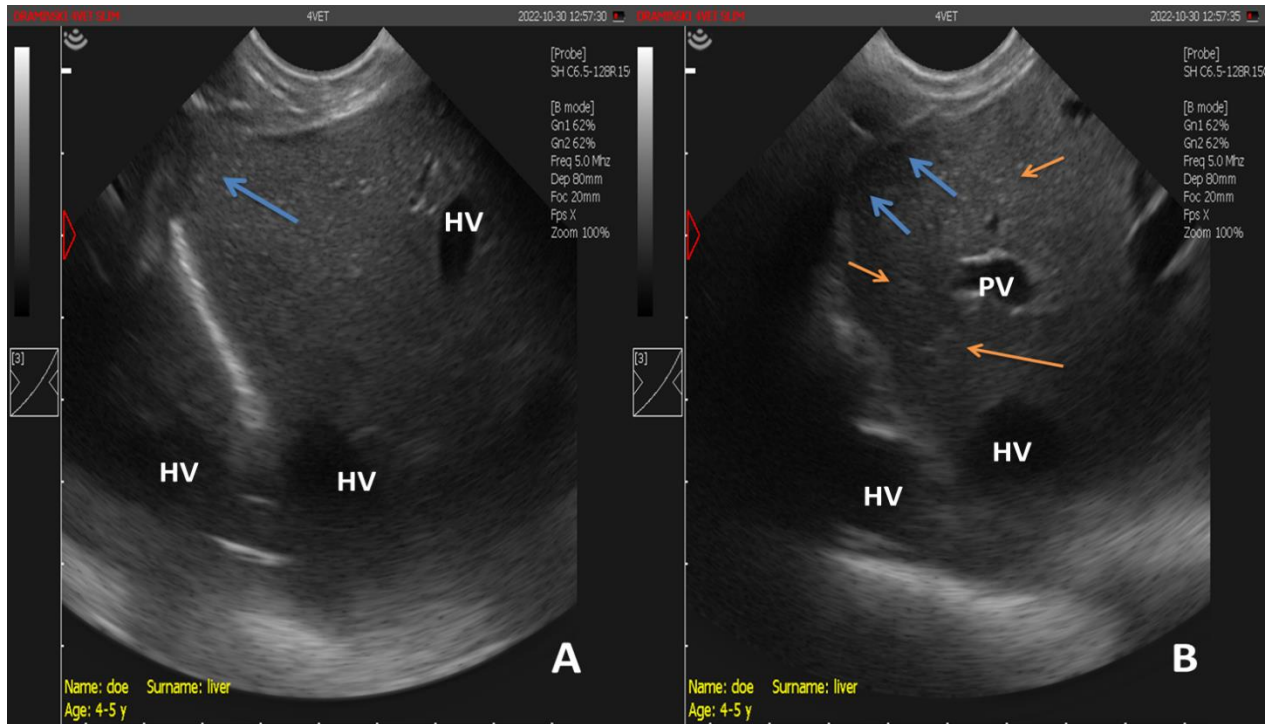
Ultra sonogram of normal hepatic parenchyma (A) Indicates normal liver echogenicity, hepatic vein (HV) showing mirror image artifact. The bluish arrows indicate pointed margins (normal liver size). Ultrasound scan of the liver in SCPT does (B) Indicates fatty liver infiltration represented by hyper echoic areas (orange arrows) showing increased echogenicity of the liver parenchyma than the normal with visible hepatic vessels; note the margins of the liver are rounded (blue arrows).
